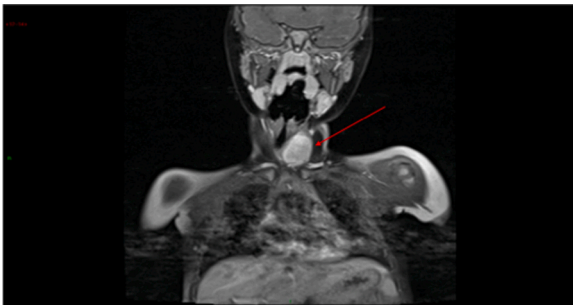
MRI scan demonstrating thyroid lesion with tracheal deviation in Child 1.
